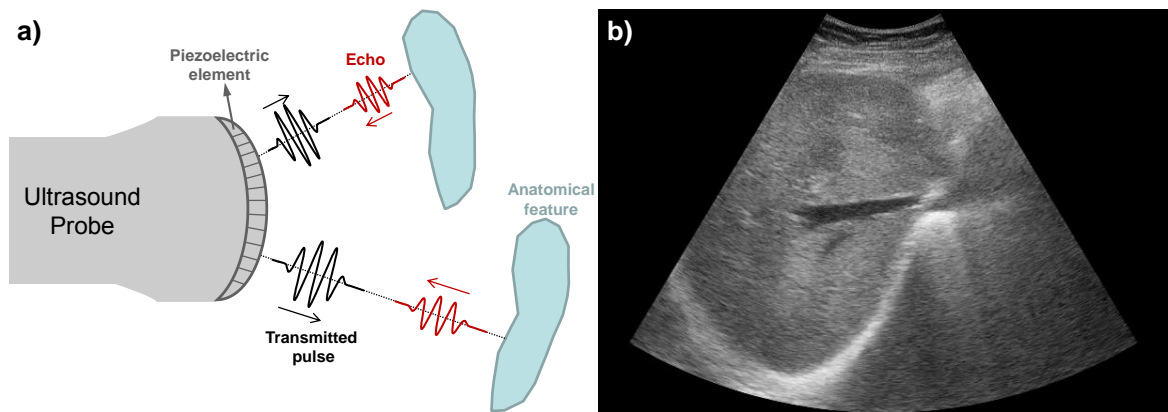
a) Demonstration of the pulse-echo principle used in ultrasound imaging. Pulses are transmitted from the ultrasound probe and echoes are reflected from the patient's anatomical features. The time delay between the echoes along with their amplitudes is used to construct an image of the patient's anatomy. b) Example of an ultrasound tissue image of the liver.
